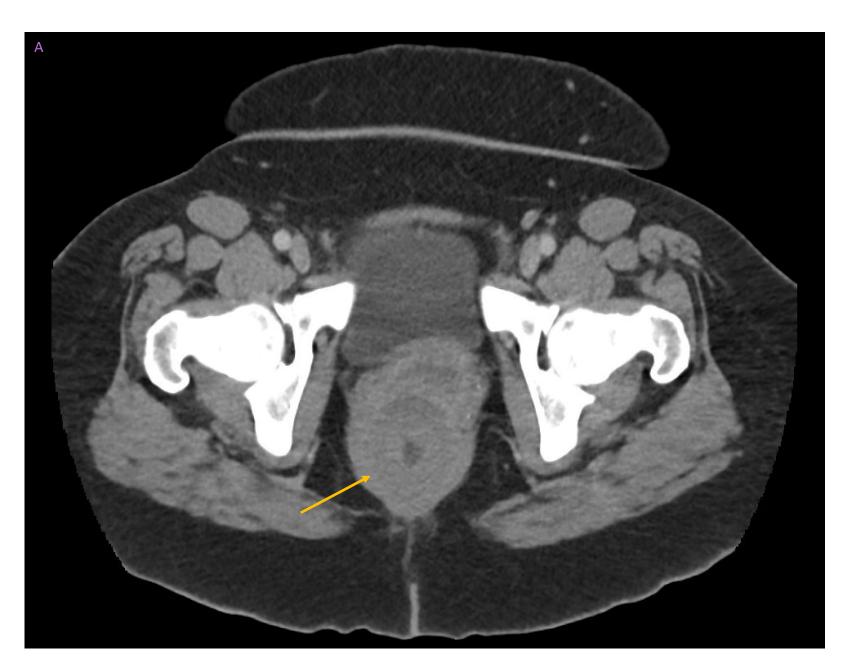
Cross-sectional and endoscopic imaging of our patient with HGSC of Müllerian origin presenting with an anal and rectal mass. CT (A) axial and (B) coronal views, the mass indicated by the yellow arrows. (C) Flexible sigmoidoscopy revealing a malignant-appearing tumor in the mid rectum, biopsied.
